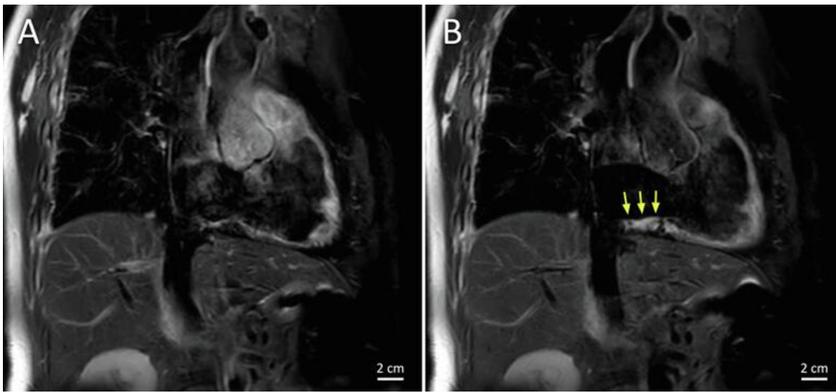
Imaging with T2 mapping detects inflamed edematous tissue. A and B: T2-weighted magnetic resonance images of the cavotricuspid isthmus in the RAO view before (A) and after (B) ablation showing edema in the ablation lesions, indicated by the yellow arrows. Citation: Bijvoet GP, Holtackers RJ, Nies HMJM, Muhl C, Chaldoupi SM. The role of interventional cardiac magnetic resonance (iCMR) in a typical atrial flutter ablation: The shortest path may not always be the fastest. *Int J Cardiol Heart Vasc* 2022; 41: 101078. [PMID: 35800043 DOI: 10.1016/j.ijcha.2022.101078]. Copyright © 2022 The Authors. Published by Elsevier B.V. (Reproduced under the terms of the Creative Commons CC-BY license)[44].
